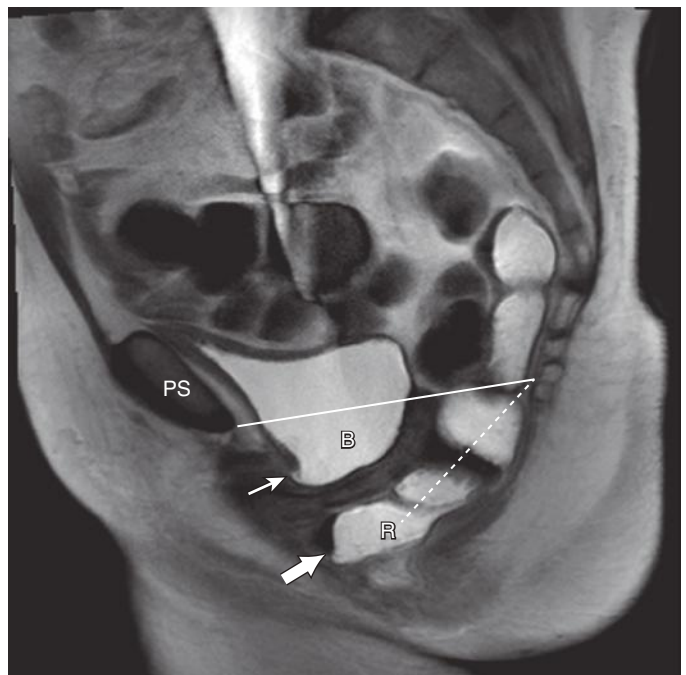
Cystocele with urethral rotation on sagittal strain magnetic resonance image. Sagittal T2-weighted image of the pelvis during strain demonstrates multicompartmental descent of the pelvic organs. The urinary bladder (B) is well below the pubococcygeal line (solid line). Posterior plate descent (dotted line) and rectocele (thick arrow) are also present. Of note, there is significant rotation of the urethra with nearly horizontal course (thin arrow). PS, pubic symphysis; R, rectum.
